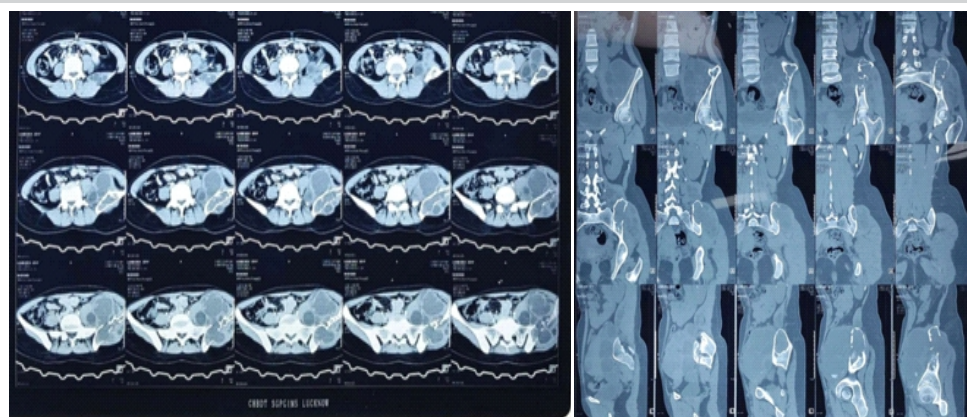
(a) Patient's computed tomography (CT) pelvis showing involvement of lesion in the left iliac bone, surrounding multiloculated lesion involving the iliopsoas and gluteus medius muscles. (b) Patient's CT pelvis coronal section showing involvement of the lesion in the left iliac bone.
